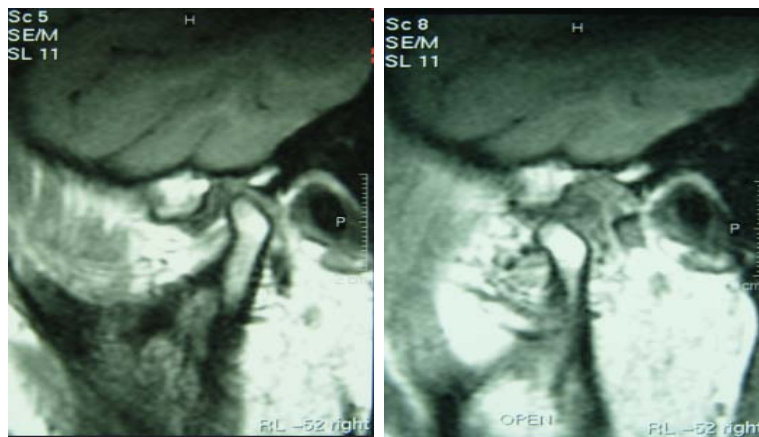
MRI sagittal view of condyle-disc complex in closed (left) and open position (right) at reversible status
